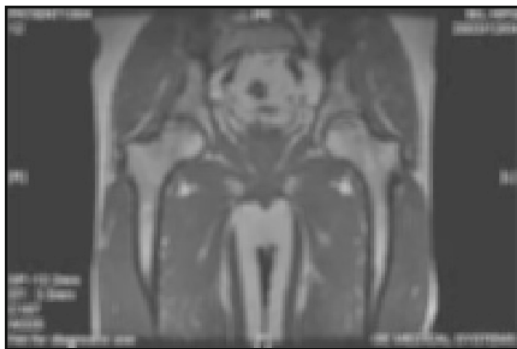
T1-weighted magnetic resonance imaging (MRI) scan showing areas of peripheral serpiginous low signal with osteonecrosis affecting approximately 75% of the articular surface on the right and 50% on the left, without femoral head collapse, in a testicular cancer patient with delayed non-traumatic osteonecrosis following chemotherapy (figure 1 and figure 2 show the same patient).
